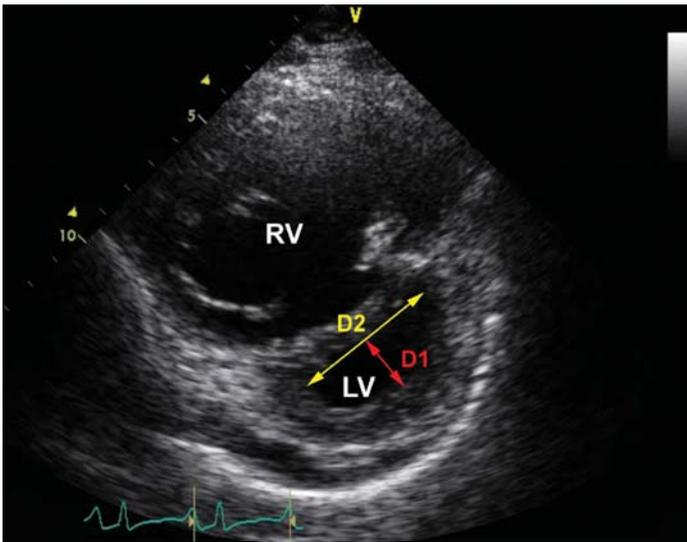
Left ventricular eccentricity index, as assessed from the parasternal short axis, at the level of the papillary muscles. As pressure overload and hypertrophy increase, the right ventricle (RV) tends to dominate chamber interaction and the interventricular septum flattens or bulges into the left ventricle (LV) with impairment of left ventricular function. Left ventricular eccentricity index (LV-EI) can be calculated by the formula $LV-EI = D2/D1$, where D2 is the diameter parallel and D1 is perpendicular to the interventricular septum; abnormal values are > 1.2 , normal values $LV-EI_{sys} = 1.00 \pm 0.06$, $LV-EI_{dia} = 1.01 \pm 0.04$
